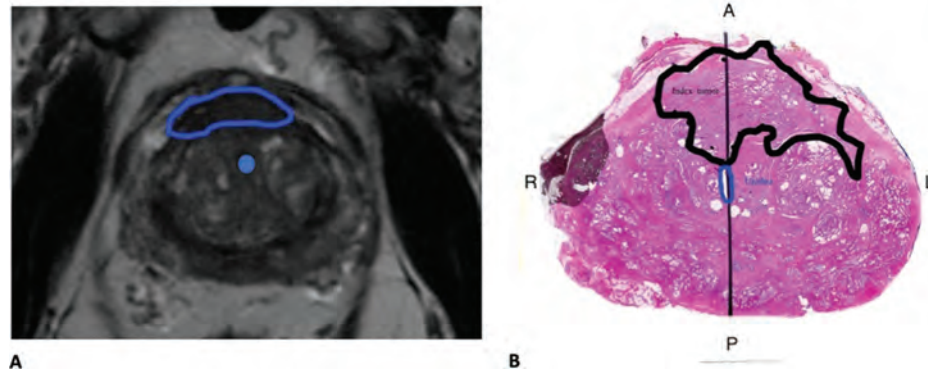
Example of a discordant MRI region of interest reported being 6 mm away from urethra but that was abutting the urethra on whole-mount pathology. A, MRI T2-weighted image showing region of interest (blue outline) is away from the urethra (blue dot). B, Whole-mount pathology shows lesion (black outline) abutting urethra (blue outline). A indicates anterior; L, left; P, posterior; R, right.
